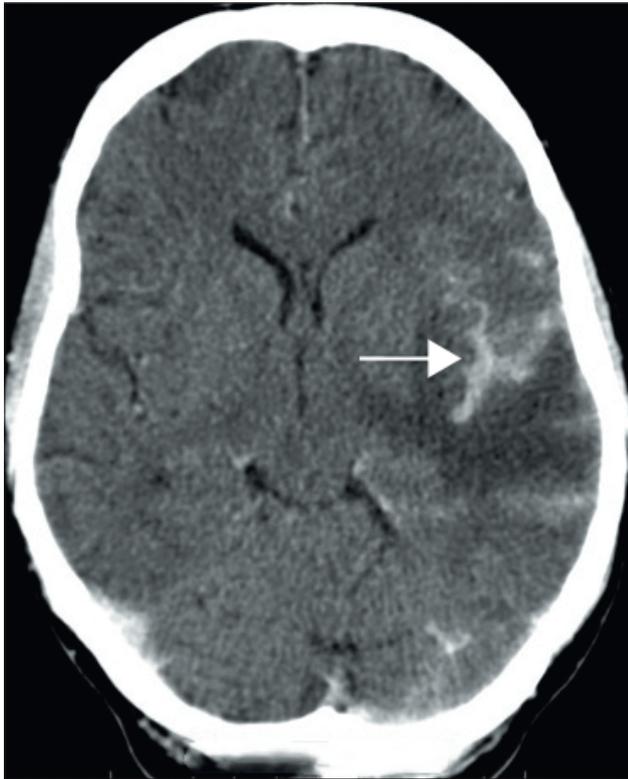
Computed tomogram of a patient with tuberculous meningitis immune reconstitution inflammatory syndrome. This contrast-enhanced axial image shows focal leptomeningeal enhancement of the left hemisphere with marked involvement of the sylvian fissure (white arrow) and adjacent cerebral oedema.
